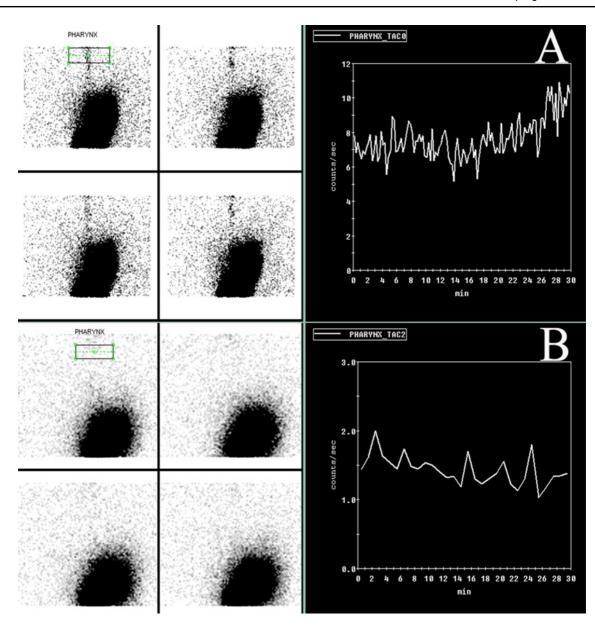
Typical graphic analysis showing computer-generated count for isotope contamination in the pharynx. To the left of the screen, there are scintigraphic images marked for counting and to the right of the screen graphs showing results for the areas marked. Y-axis
